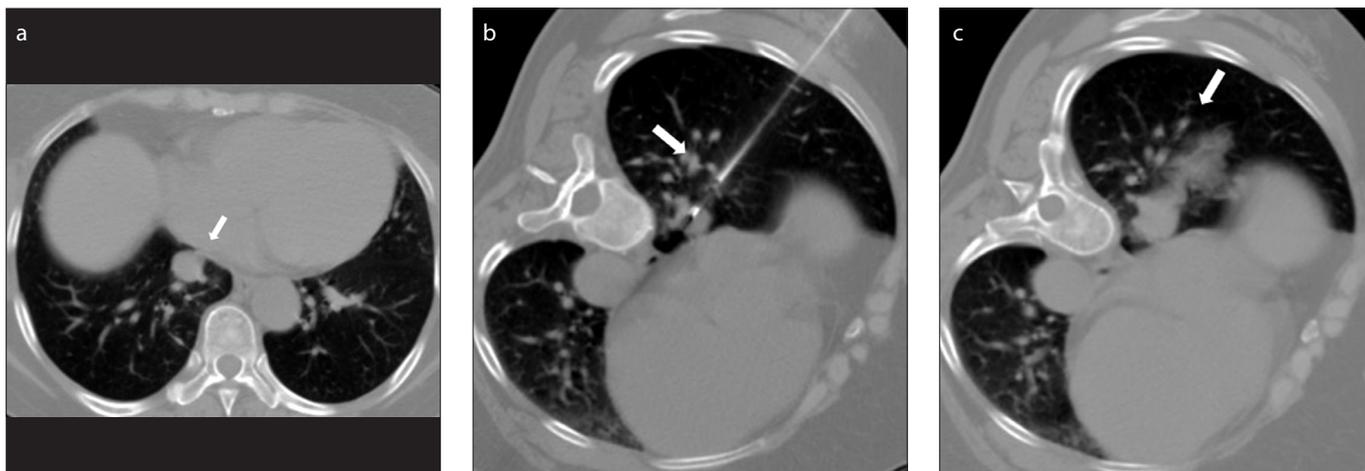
a–c. CT-guided core biopsy of a small nodule in a 58-year-old woman. CT image (a) obtained before biopsy with patient in supine position shows a 17 mm lung nodule in the right lower lobe. The nodule is within 10 mm of the right atrium. CT image (b) obtained after needle placement shows the precise localization of the tip of the biopsy needle in the nodule. The length of needle trajectory through the lung parenchyma is 100 mm. CT image (c) obtained after needle removal shows grade 2 hemorrhage along the needle tract. The core biopsy diagnosis was adenocarcinoma, which was the final diagnosis after surgical resection.
